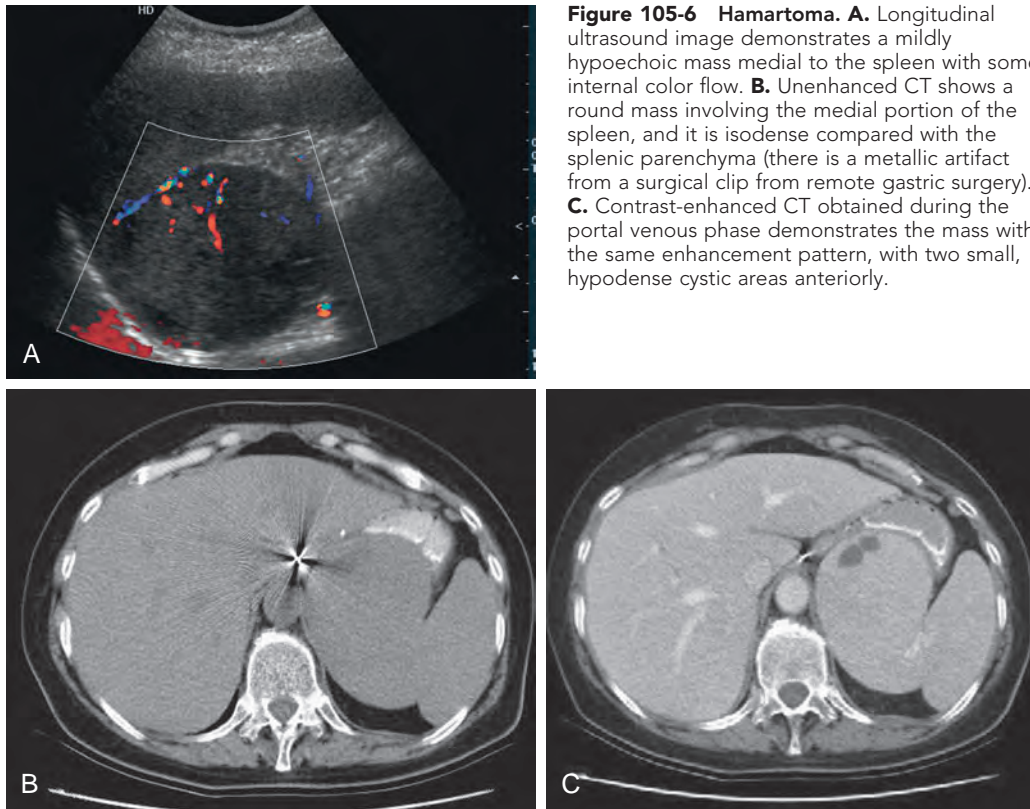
Hamartoma. A. Longitudinal ultrasound image demonstrates a mildly hypoechoic mass medial to the spleen with some internal color flow. B. Unenhanced CT shows a round mass involving the medial portion of the spleen, and it is isodense compared with the splenic parenchyma (there is a metallic artifact from a surgical clip from remote gastric surgery). C. Contrast-enhanced CT obtained during the portal venous phase demonstrates the mass with the same enhancement pattern, with two small, hypodense cystic areas anteriorly.
